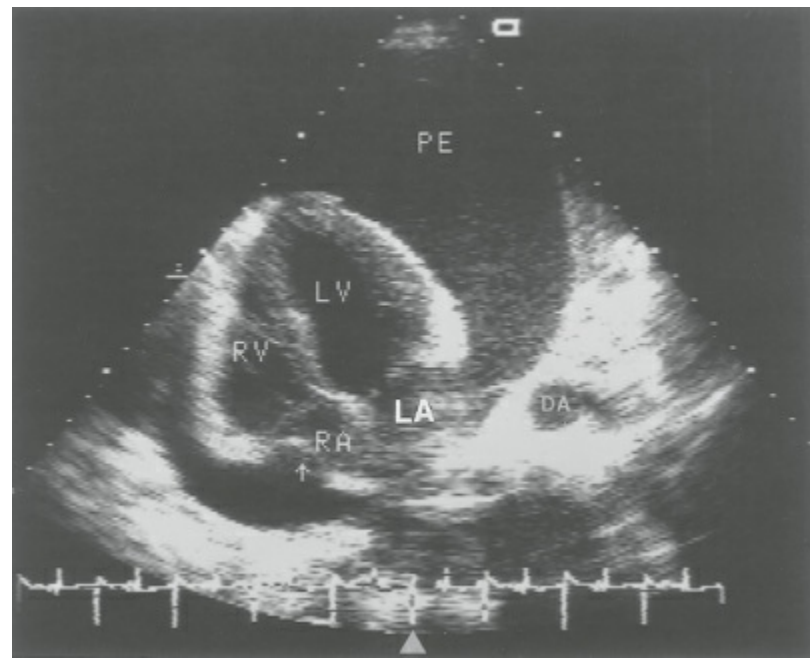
The echocardiogram shows a large pericardial effusion with diastolic right atrial collapse (*arrow*). (From Joffe II, Jacobs LE, Kotler MN. Pericardial tamponade. *Circulation* 1996;94:2667, with permission.)
